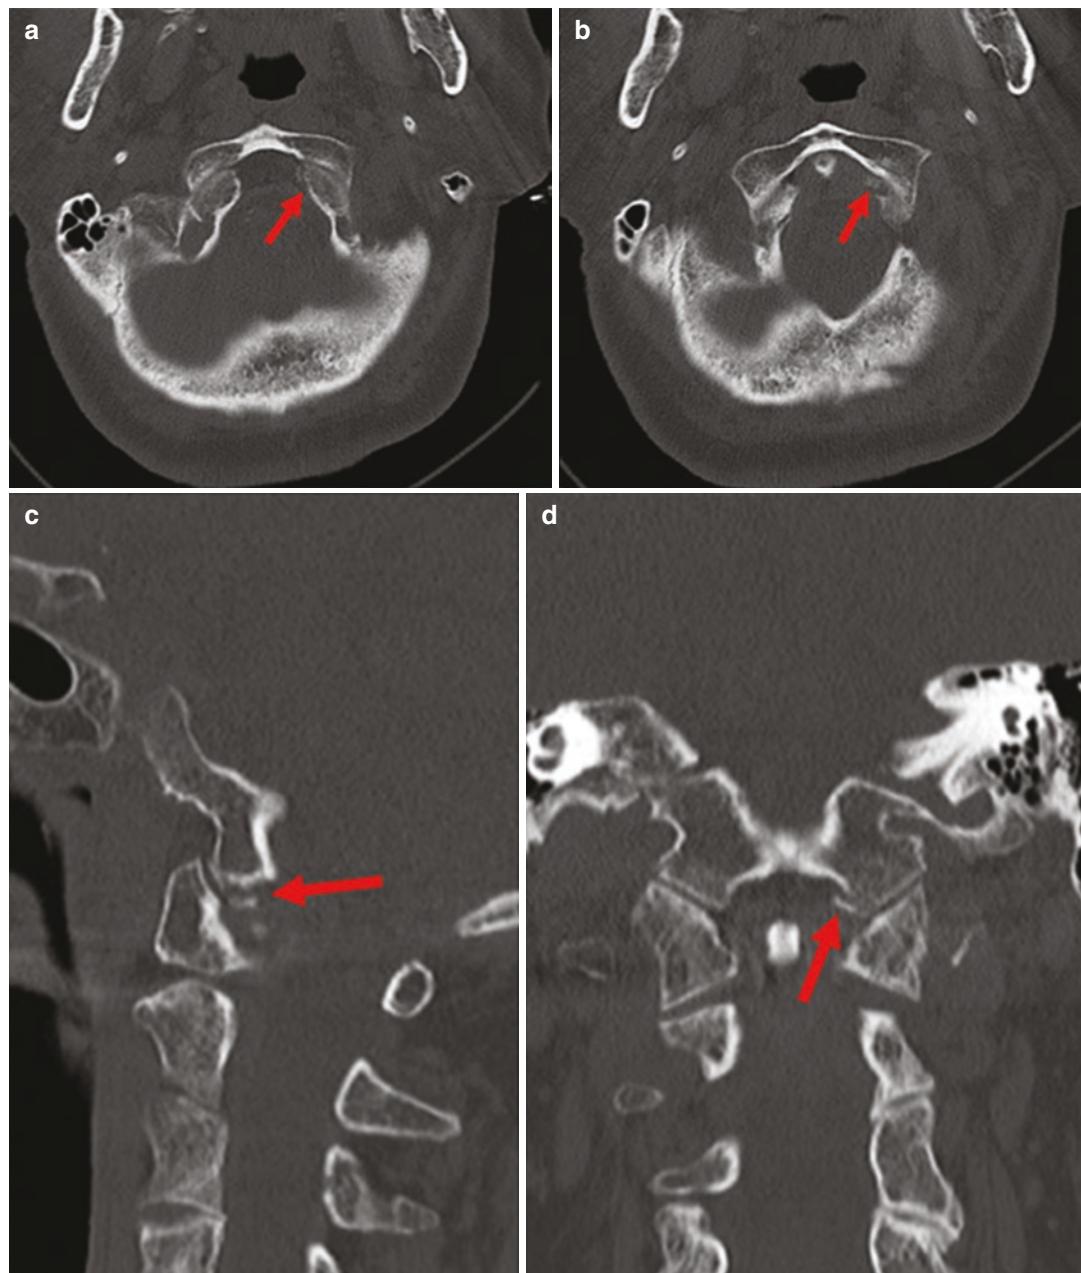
Cervical spine CT with (a, b) axial images and (c) sagittal and (d) coronal reformations showing a Type 3 occipital condyle fracture (red arrows) in a 76-year-old woman with a fall from a standing height
